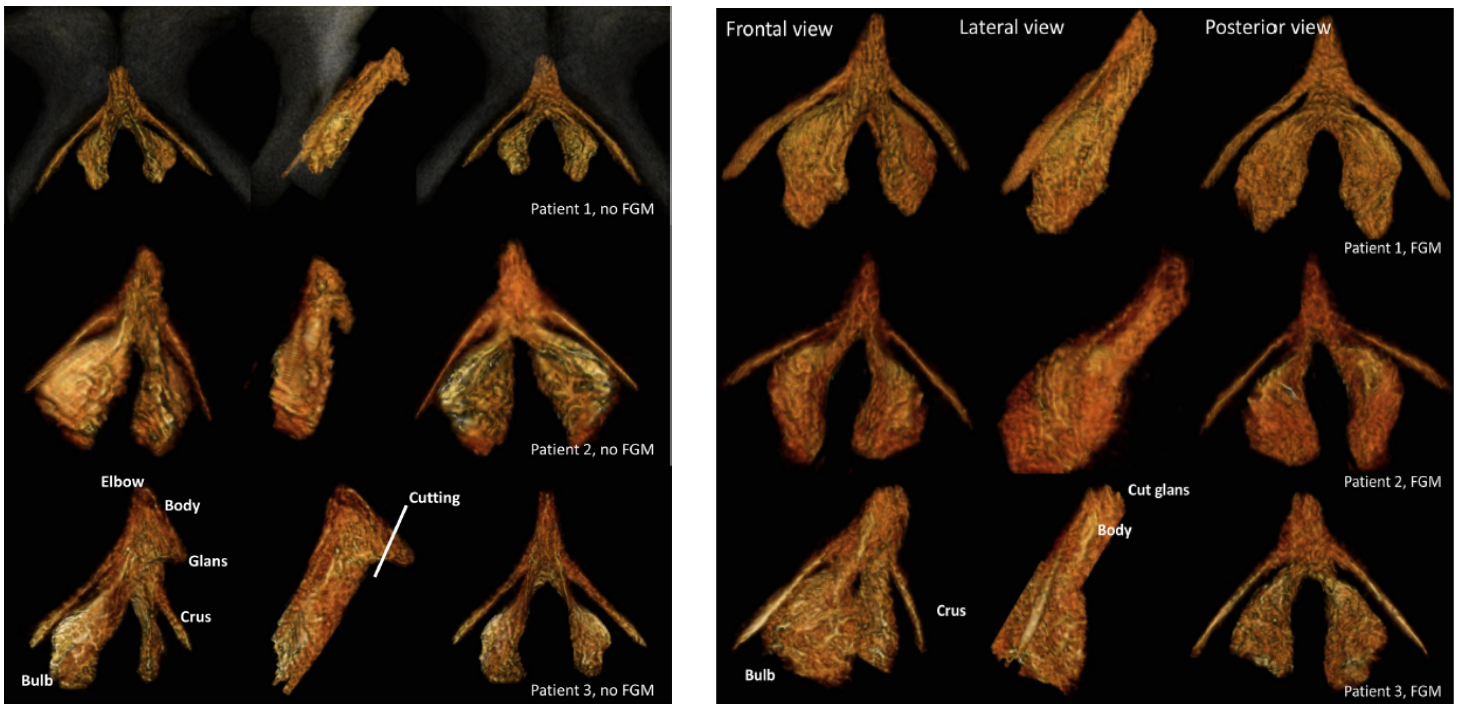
3D MRI comparing intact clitoris and clitoris of patient with FGM.
